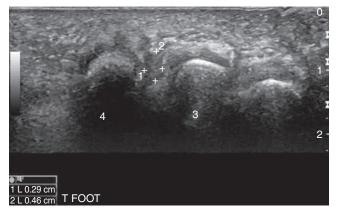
Transverse sonogram of the left metatarsal bones.
